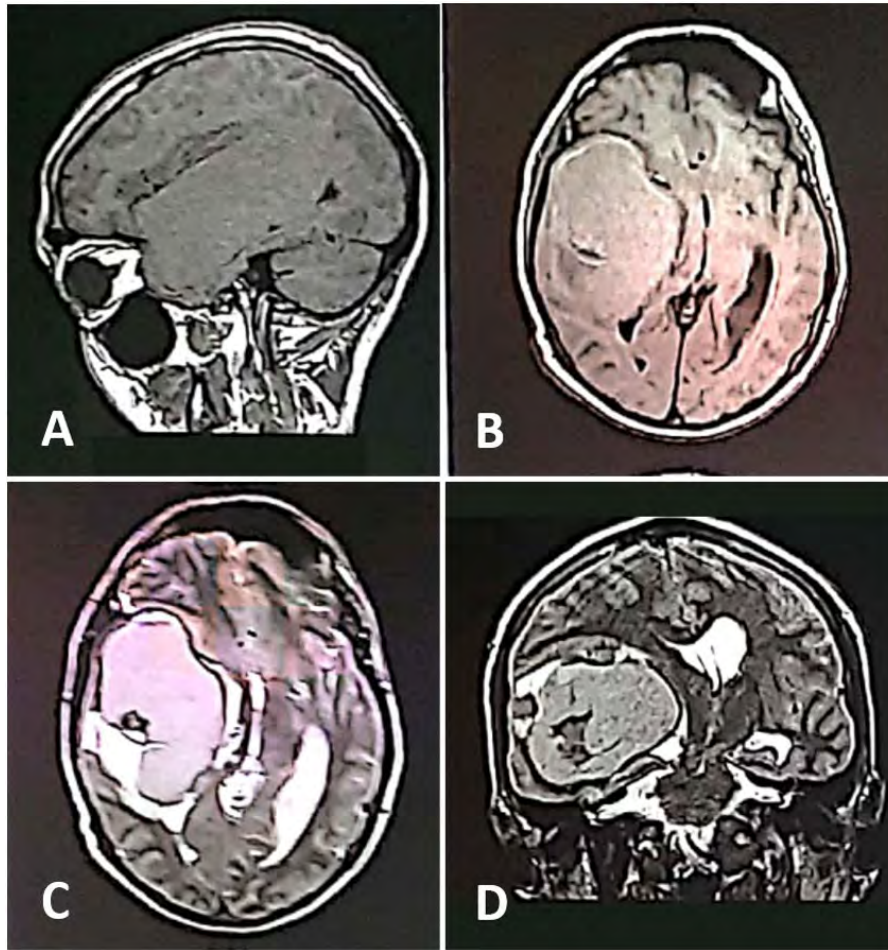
Pre-operative CT. A. T1, sagittal view. B. Flair, axial view. C. T2, axial view. D. T2, coronal view.
